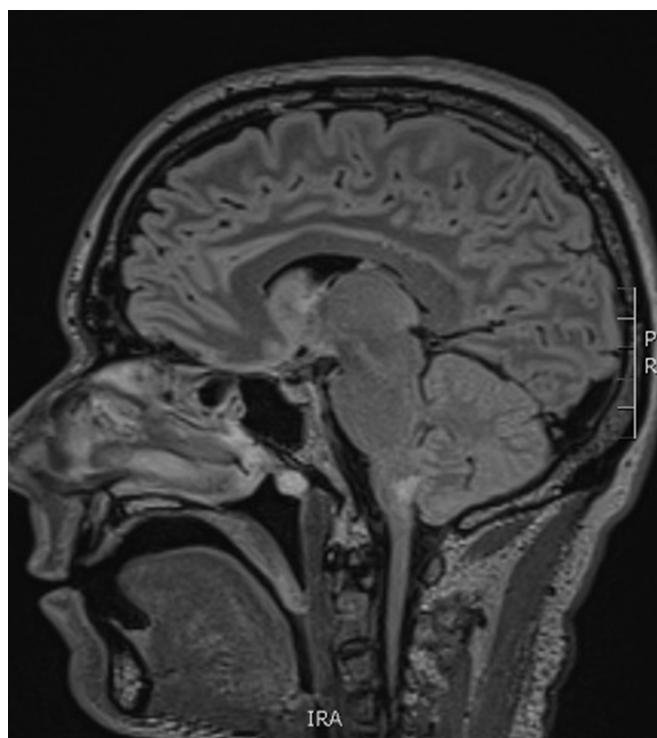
Sagittal image of MRI brain showing an infarct in the right posterior inferior cerebellar artery territory.
